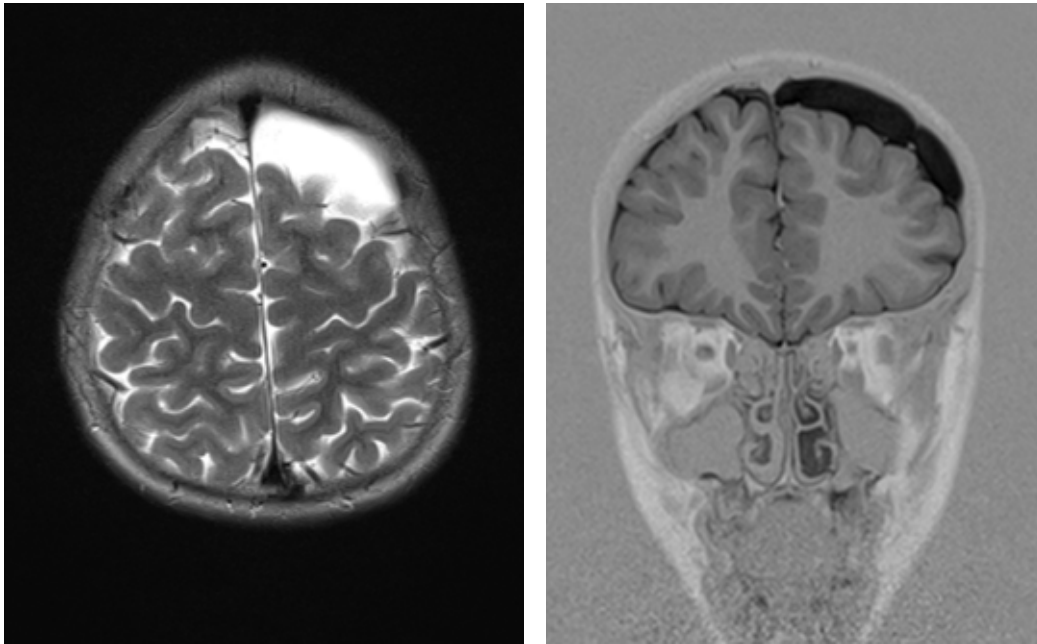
Case 3—Brain MRI demonstrating an arachnoidal cyst over the left frontal lobe
